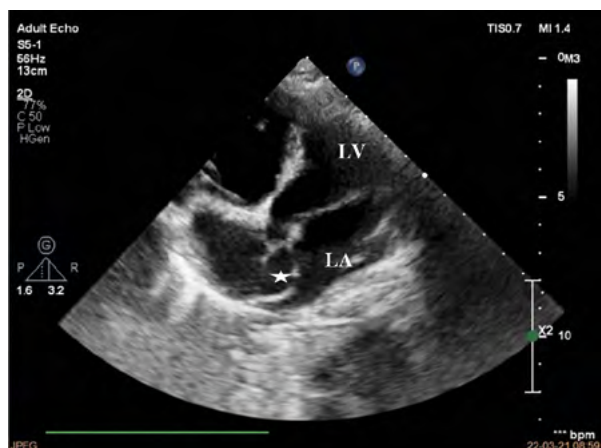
Echocardiography, 4-chamber view. In the LA additional septum. Free space and no thrombus between 2 layers (asterisk); LA – left atrium; LV – left ventricle
